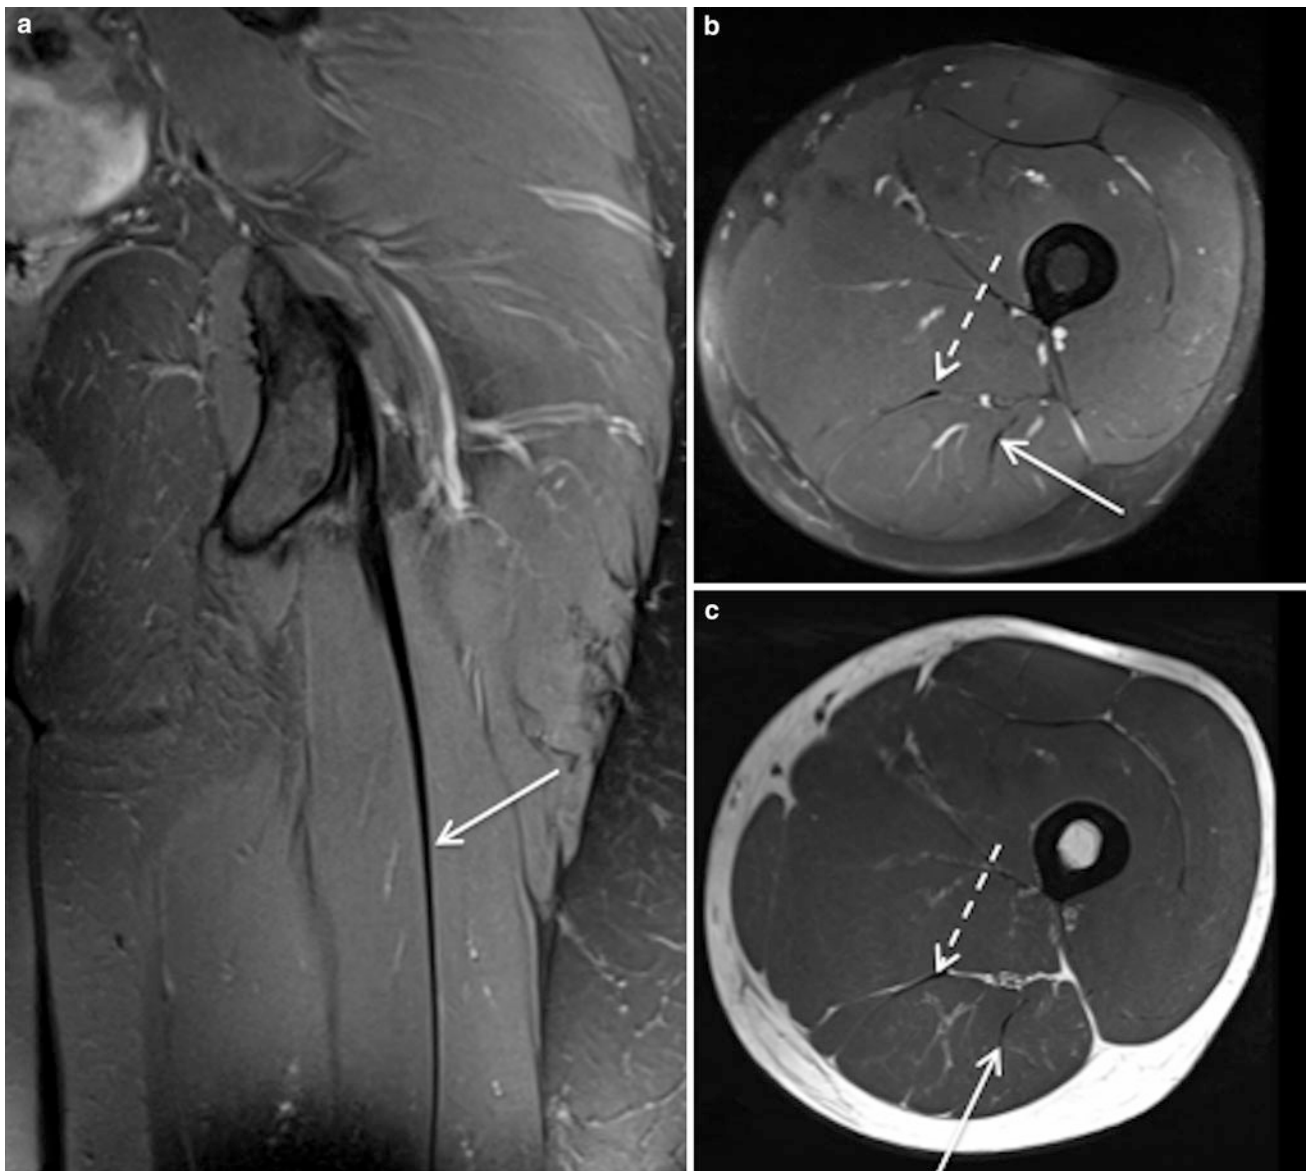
Coronal proton density weighted MR image with fat saturation (a) and axial proton density weighted MR images, with and without fat saturation (b and c respectively) demonstrates the normal proximal
